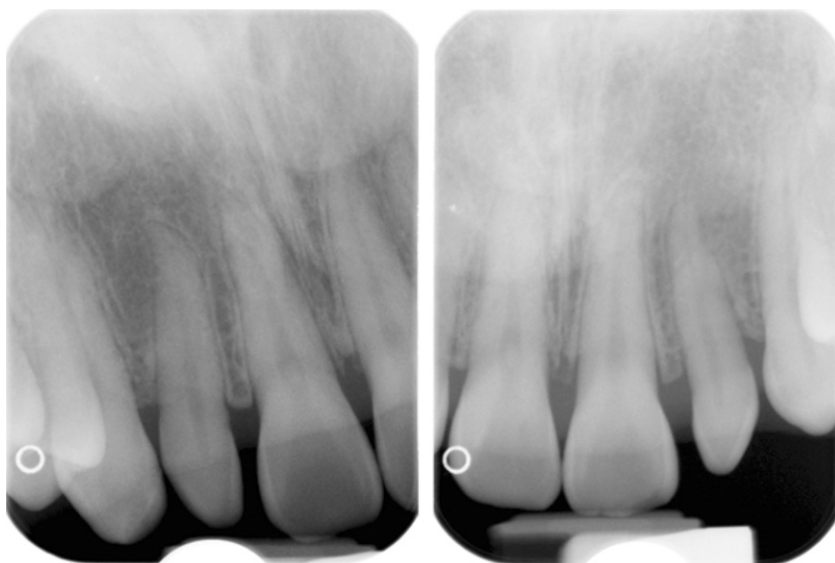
Radiographs showing sound maxillary teeth and normal periapical tissue.
